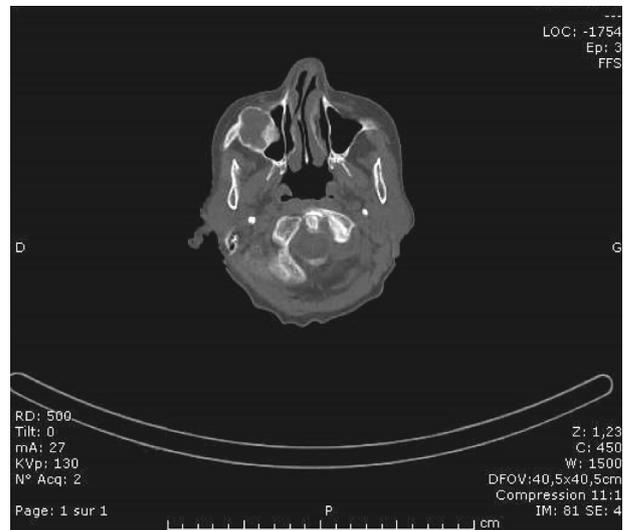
Axial CT scan of the facial bones, bone window setting, showing a tumour invading the right maxillary sinus, rupturing the cortex.
